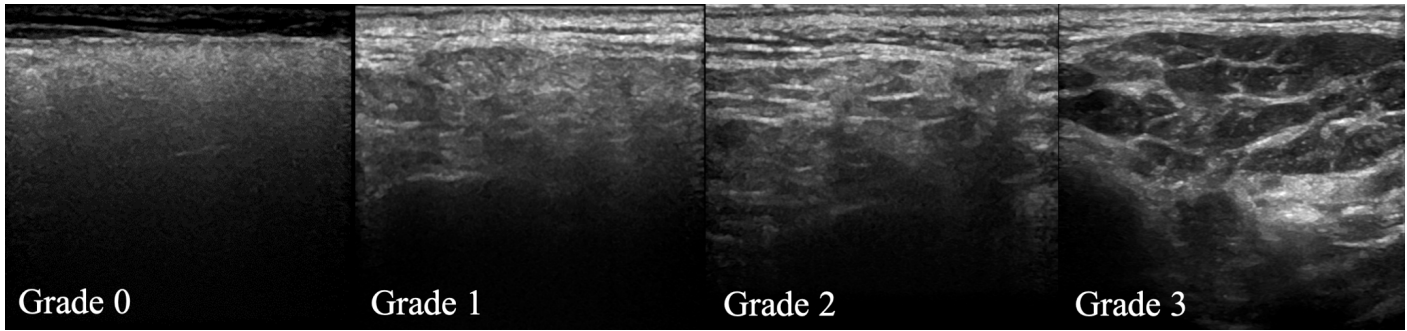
Representative parotid gland greyscale ultrasound images demonstrating Grades 0 to 3 according to the 2019 OMERACT scoring system^[9]
